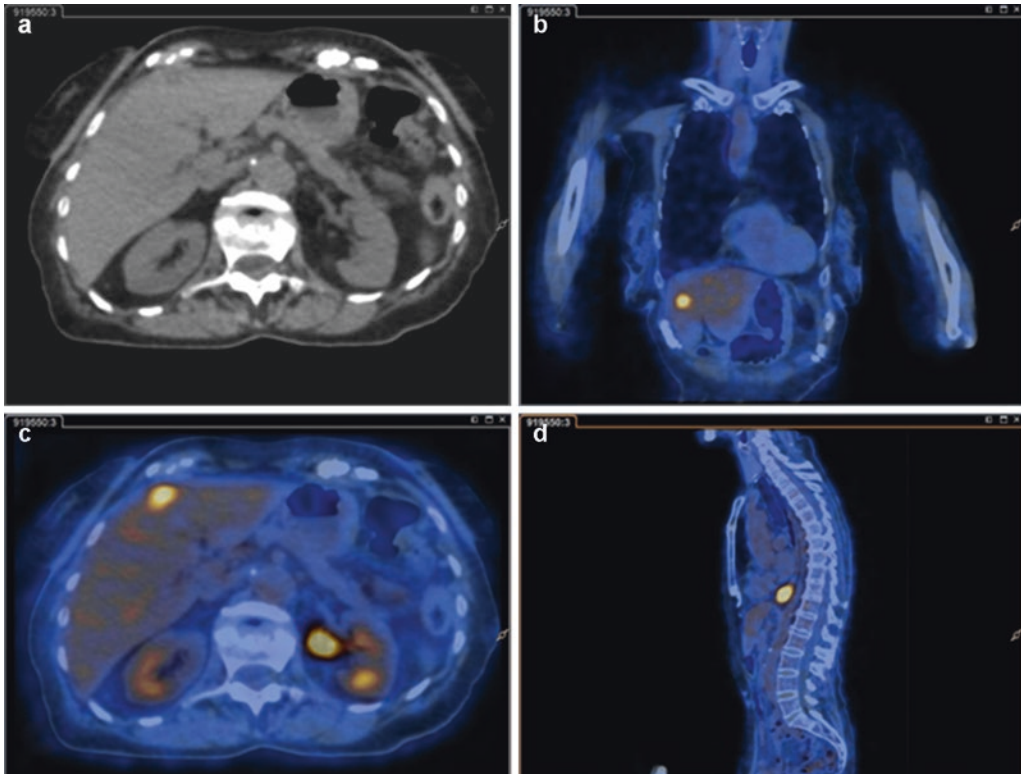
EGJ cancer with metastatic disease. Evidence of metastatic liver disease at initial staging. At CT scan (a) a small hypodensity is seen on liver's IV segment. PET/CT
